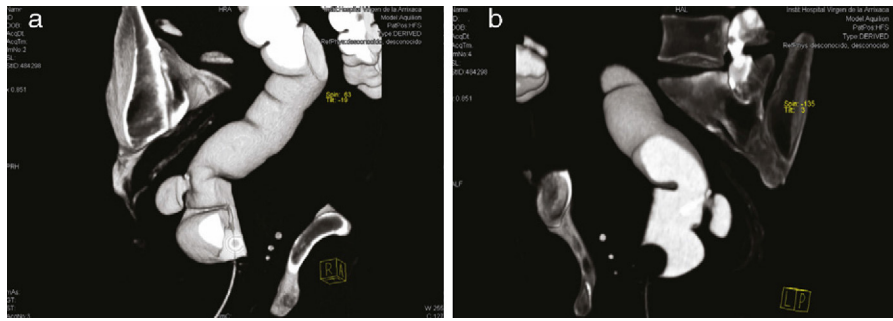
(a) and (b) CT images in which a solitary 3-cm diverticulum in the posterior side of the rectum can be seen.
